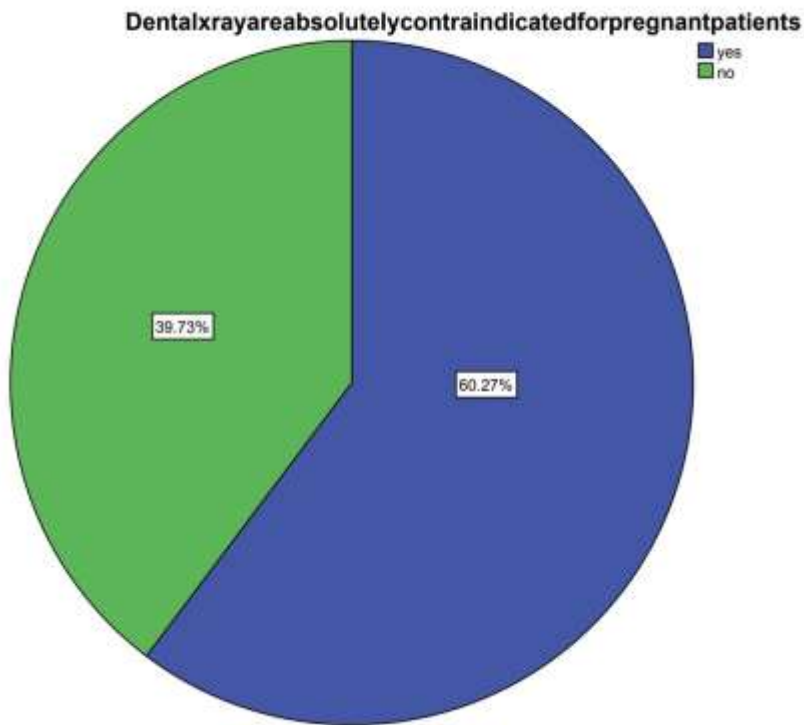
This pie chart depicts the percentage of participants who feel that dental x-rays are absolutely contraindicated for pregnant women. In this figure the blue represents the responses 'yes' (60.27%) and green represents the responses 'no' (39.73%)
